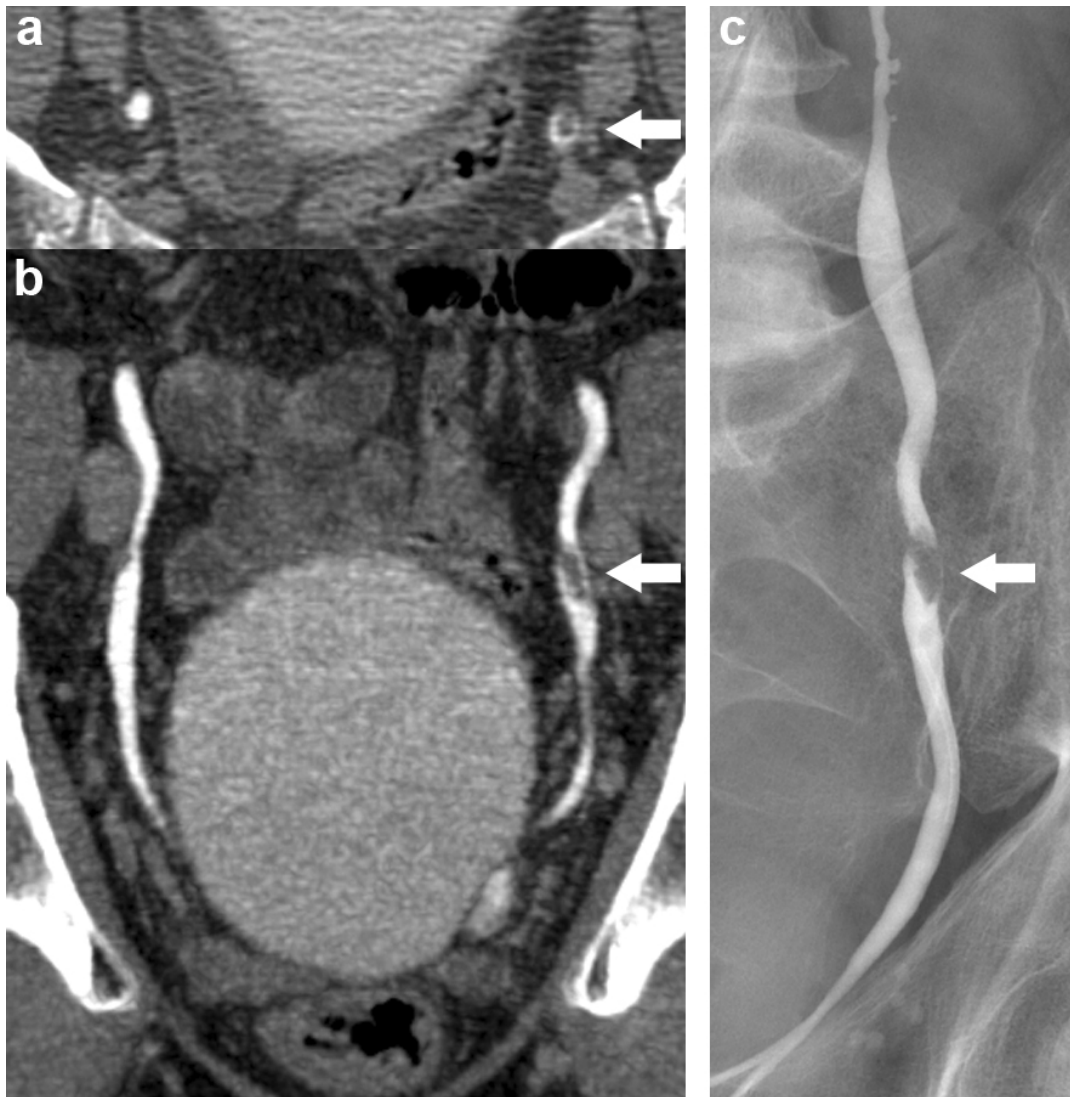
66M with urothelial carcinoma of left ureter and bladder. (a) Axial and (b) coronal images from excretory-phase CT urography demonstrating filling defect in the ureter (arrows), with no associated hydronephrosis. (c) RUP and biopsy confirms UTUC.
